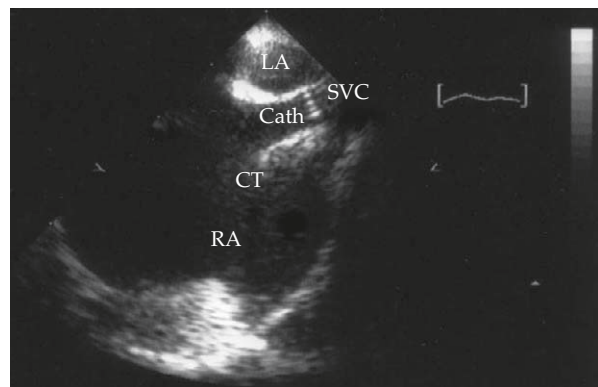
A central venous catheter advanced in the superior vena cava–right atrium (SVC-RA) junction shown on transesophageal echocardiography. The catheter (Cath) was advanced near the SVC-RA junction, as defined by the superior border of the crista terminalis (CT) in the right atrium (RA). LA = left atrium.
